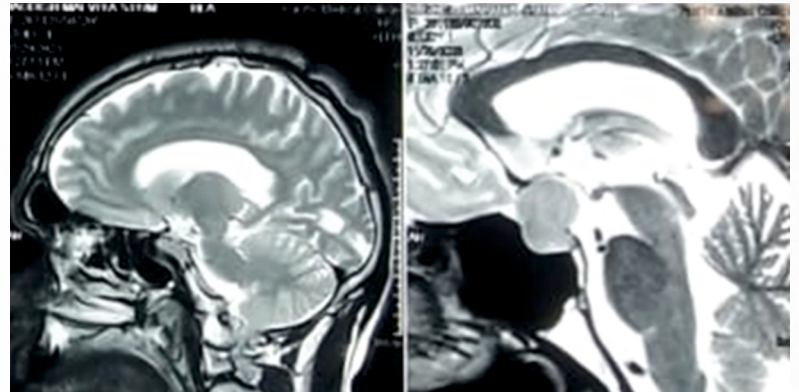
MRI pituitary showing Macroadenoma with suprasellar extension
